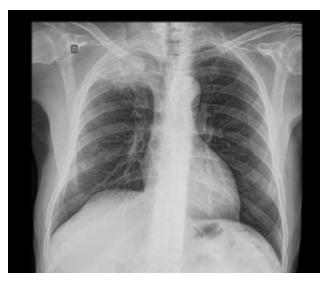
The tumor in Pancoast syndrome in this chest radiograph is in the apex of the right lung. Source: https://radiopaedia.org/articles/pancoast-tumour. Case courtesy of Dr Bruno Di Muzio, Radiopaedia.org, rlD: 29403.
